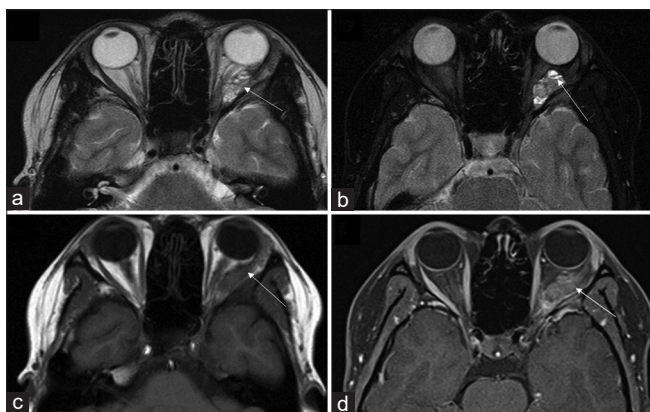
T2-weighted image (a) showing a fairly well-defined heterogeneous hyperintense left intraconal mass between the optic nerve and lateral rectus muscle, with medial displacement of the optic nerve and mild proptosis. T2 fat-saturated image (b) showing the mass has a cystic component. T1-weighted image (c) showing this mass is an isointense to the recti muscle and optic nerve. T1 fat-saturated postcontrast image (d) showing the mass with heterogeneous contrast enhancement (arrow)
